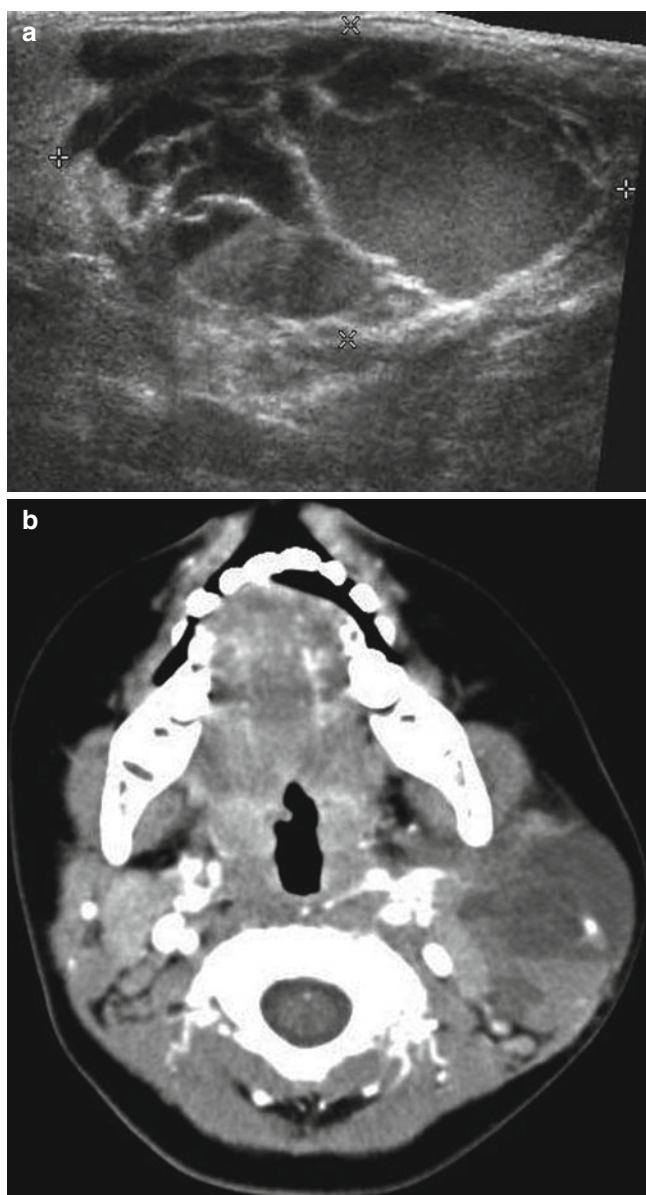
Lymphangioma of the parotid gland in a 22-month-old boy. (a) US shows a multiseptated cystic mass with internal debris in some of the chambers. (b) Contrast-enhanced axial CT scan shows a large, thin-walled, multiseptated mass with fluid–fluid levels in the left parotid gland
